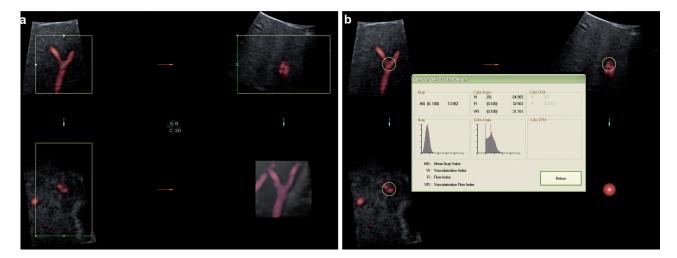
Analysis of a sphere-shaped volume in a three-dimensional power Doppler image sample around (a) a user-defined reference point (green x in upper left hand corner) with Virtual Organ Computer-aided AnaLysis (VOCAL) software. (b) Small sphere volume analysis with the corresponding histogram showing its vascularisation index (VI), flow index (FI) and vascularisation flow index (VFI).
